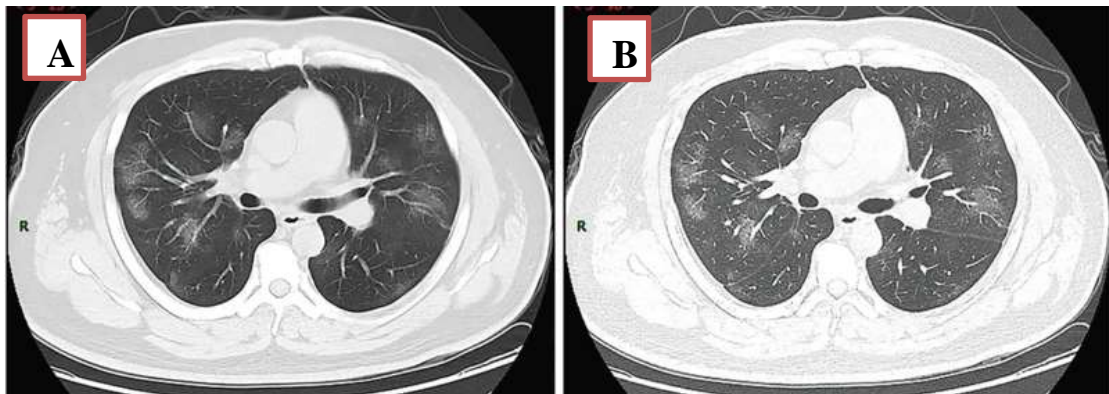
Image A is a computed tomography of a rapid stage of COVID-19 disease. Image B is a HRCT.
